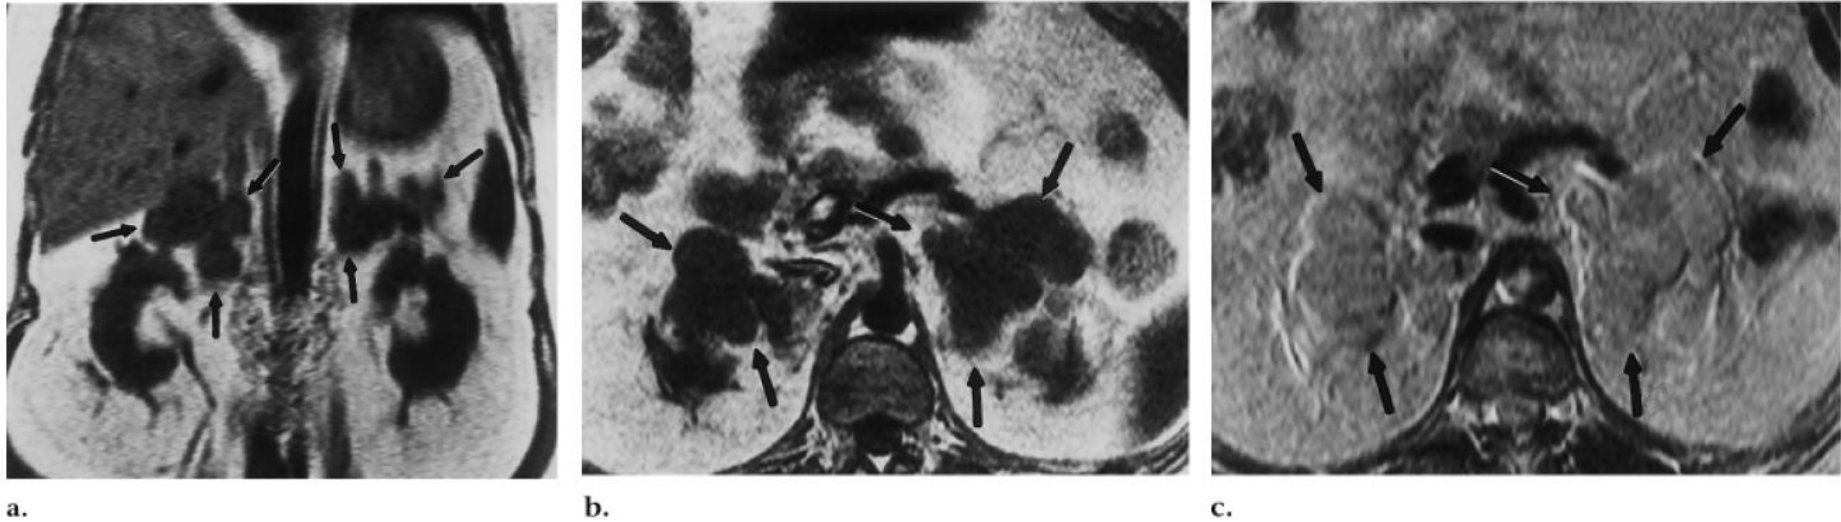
Patient 10. (a) The extent of adrenal enlargement (arrows) is well demonstrated on this coronal T1-weighted (300/10) spin-echo MR image. (b, c) Macronodular hyperplastic adrenal glands (arrows) are (b) hypointense relative to the liver on a transverse T1-weighted (300/10) spin-echo MR image and (c) minimally hyperintense on a transverse T2-weighted (2,000/80) spin-echo MR image.
